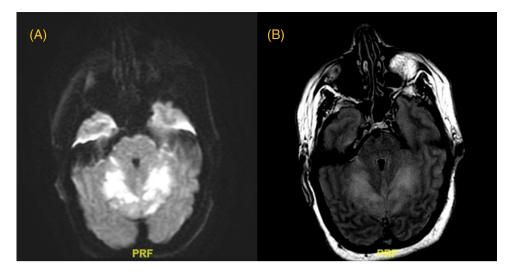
Magnetic resonance imaging axial views with large volume bilateral cerebellar infarcts and moderate volume bilateral mesial temporal lobe subacute nonhemorrhagic infarcts. (A) Diffusion weighted imaging. Positive signal suggestive of ischemia. (B) Fluid-attenuated inversion recovery. Positive signal in area of infarct suggestive of a more subacute onset of stroke. Abbreviation: PRF, posterior right foot
